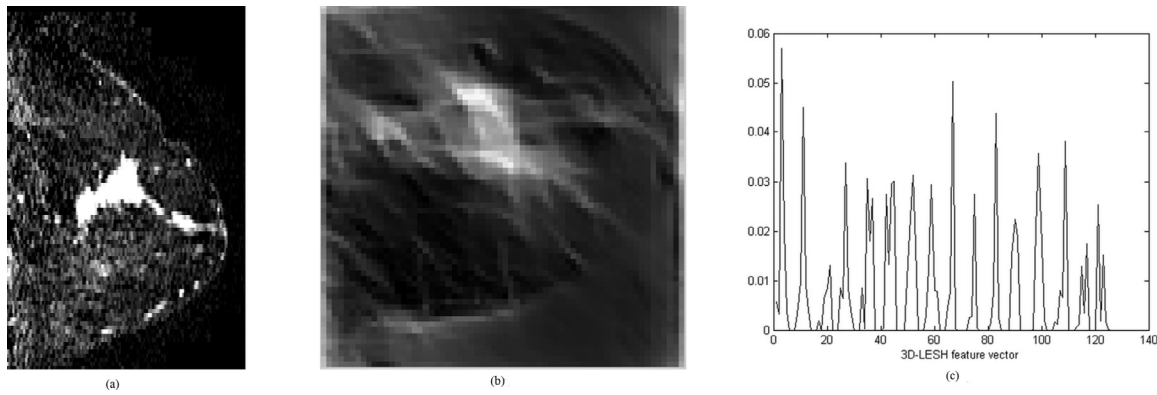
Sample T2-weighted MRI image, its local energy map and 3D-LESH feature vector plot, (a) Sample T2-weighted MRI image in sagittal view, (b) Its local energy map, and (c) 3D-LESH feature vector.
